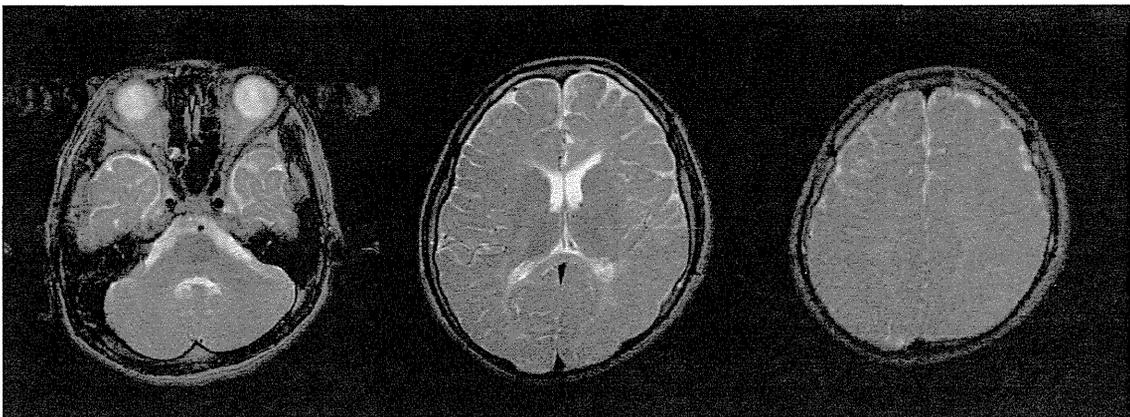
(Case 10, Type B). A 20-year-old male with Leu85Pro (c.254T>C) point mutation. The clinical stage was F2. His symptoms started at birth with nystagmus, developmental delay, quadrilateral paresis, hypotonia, spasticity, and pyramidal signs. The first MRI was performed at 15 years old. The myelination was apparently completed on T1WI (A), but the myelination age was 0–2 months old on T2WI (B). There was atrophy of the corpus callosum without cerebellar atrophy. The gap between T1WI and T2WI was evident in this case. Low signals in the posterior limb of internal capsules were identified on T2WI. This case also manifested type B imaging.
